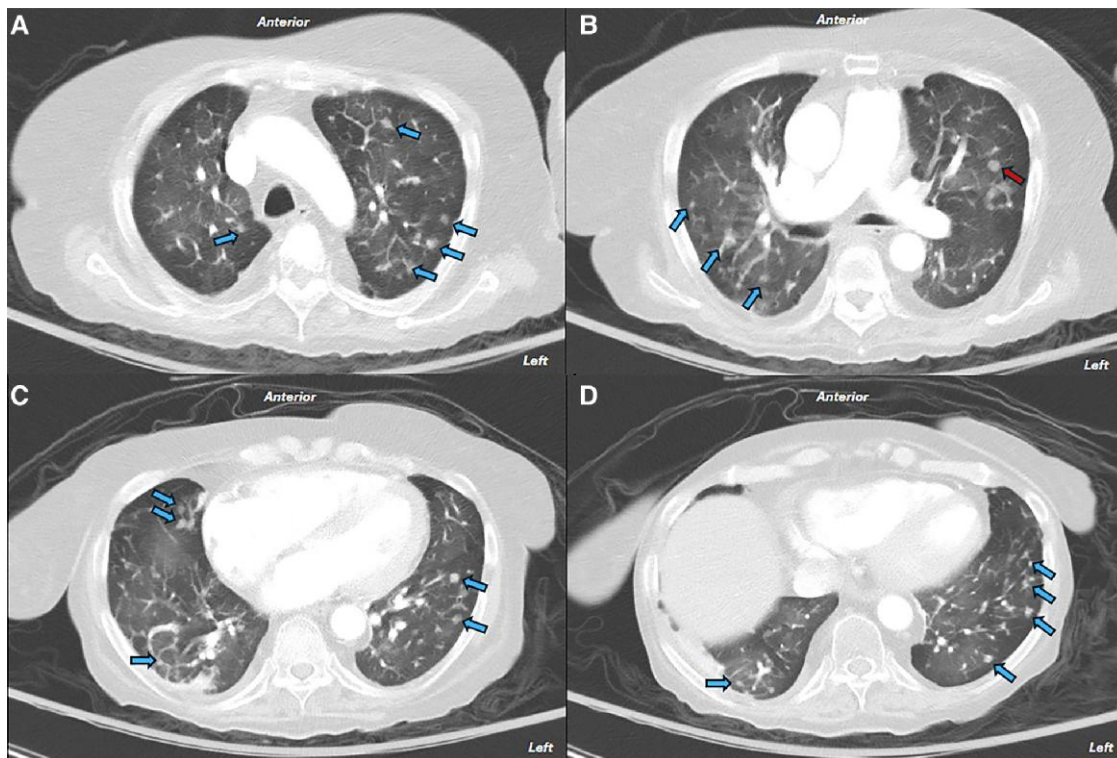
A CT scan of the chest with contrast from case #1 showing ground-glass opacities and numerous subcentimeter nodules. (A) Lung apex, (B) mid-thoracic segment, (C) mid-to-low lung bases, and (D) lower lung bases. Arrows shown in most lung field highlight some of the subcentimeter nodules, whereas in figure B left lung showed a larger nodule measuring nearly 6 mm.
